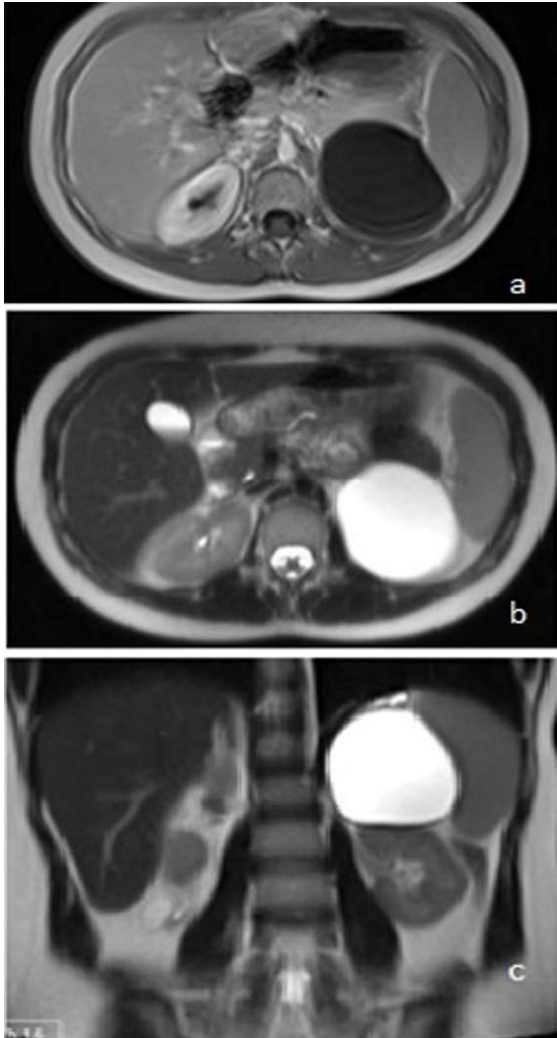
Magnetic resonance imaging had a cystic lesion with a T1 AS hypointense (a) and T2 AS hyperintense (b, c) signal at about 7 cm in the upper pole of the left kidney.
